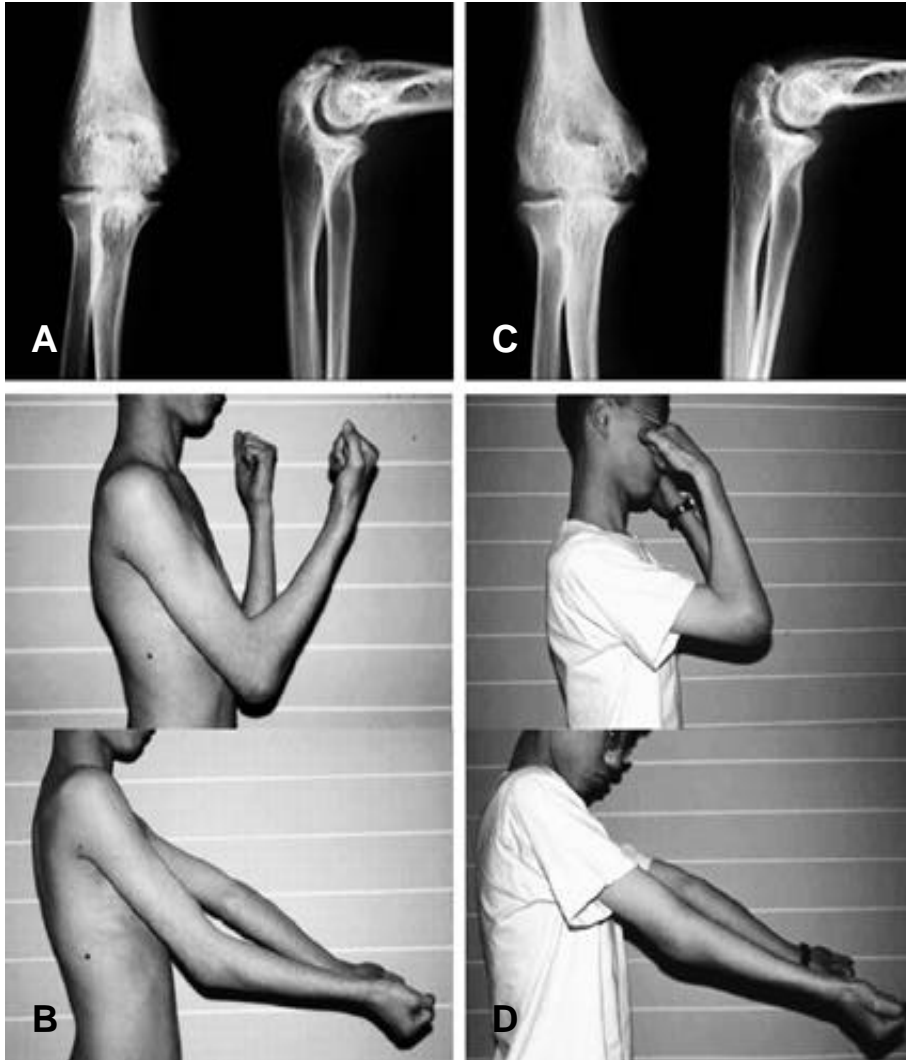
(A) Preoperative AP and lateral radiographs in a 17-year-old male with post-traumatic right elbow contracture and ectopic bone formation. He suffered a medial epicondyle fracture from Korean wrestling two years ago and subsequently underwent open reduction and internal fixation. (B) Preoperative photographs of flexion and extension of the right elbow demonstrates a decreased range of motion (40-115°). (C,D) Postoperative AP and lateral radiographs (2-C) and photographs of flexion and extension of the right elbow (2-D) (10-150°) 15 months after operation (anterior and posterior capsular release, anterior and posterior soft tissue release, ectopic bone removal).
